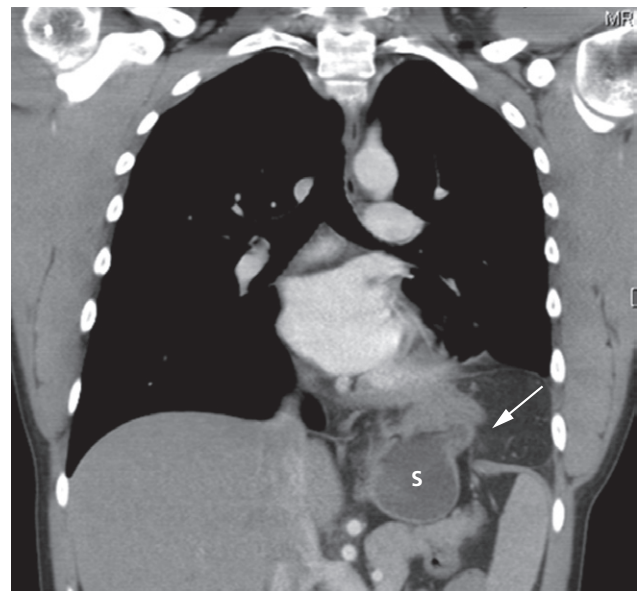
Rupture of the diaphragm. Coronal reformatted CT showing rupture of the left hemidiaphragm and resultant herniation of the stomach (S) and abdominal fat into the chest (arrow).
